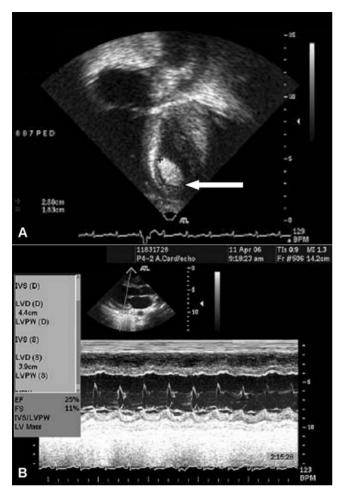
(A) The posterior angulated apical 4 chamber view showed a thrombus at the left ventricular apex, which sized was measured by  $2.9 \times 1.8$  cm. (B) M-mode showed decreased left ventricle ejection fraction.
